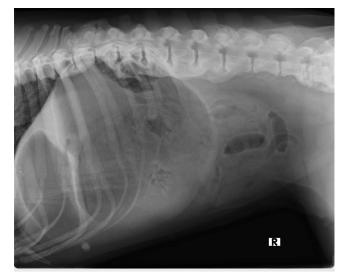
Right lateral abdominal x-ray. Notice the severe gastric meteorism and separate gas-filled pocket. Moreover, T9-T11 spondylosis and T13-L4 vertebral ankylosis are well recognized.
